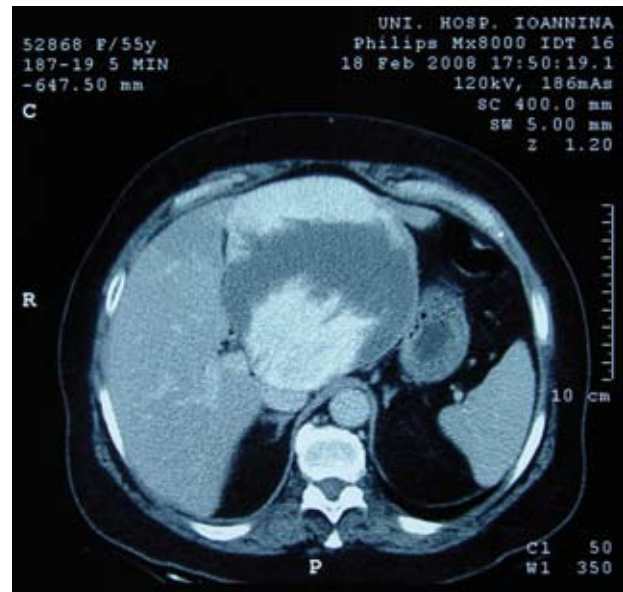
Computed tomography showing a giant liver hemangioma 13 cm in size.
